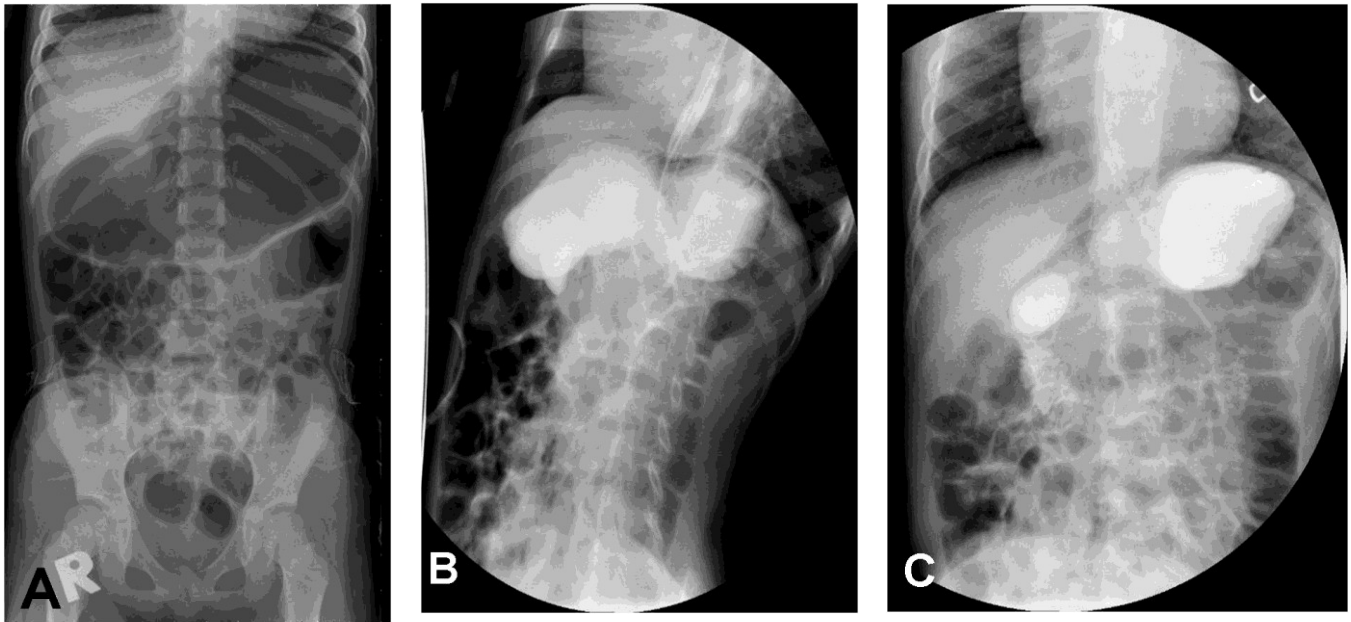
Imaging studies. (A) Plain radiograph showing hugely distended stomach, (B) Upper gastrointestinal contrast study showing distended stomach, (C) Delayed contrast film showing retained contrast in the stomach even after 120 min.*
